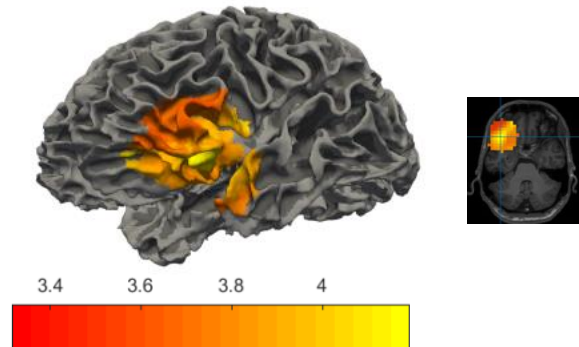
Source localisation for Patient P012 using Solution 1, 2, 3, 4 and validations. (a) Solution 1 and (b) Solution 2 were localized to the left parietal convexity concordant with the clinical propagation. (c) Solution 3 with kurtosis value 6.08 was localized the right parietal lobe. (d) Solution 4 are extending to left parietal convexity, right parietal lobe and left occipital lobe. The subfigures of (a), (b), (c) and (d) show the corresponding sources registered onto the MRI images. In the colour maps shown in (a), (b) and (c), yellow represents the highest kurtosis value and red represents the lowest values. (e) The validations used in this study, in which surgically resected areas are indicated by the blue surface and pink discs indicate the clinically localized results. The pink discs with number 1 and 2 demonstrate that the clinically localized interictal spikes originated from 1 paracentral lobule and later propagated to 2 left parietal convexity.
